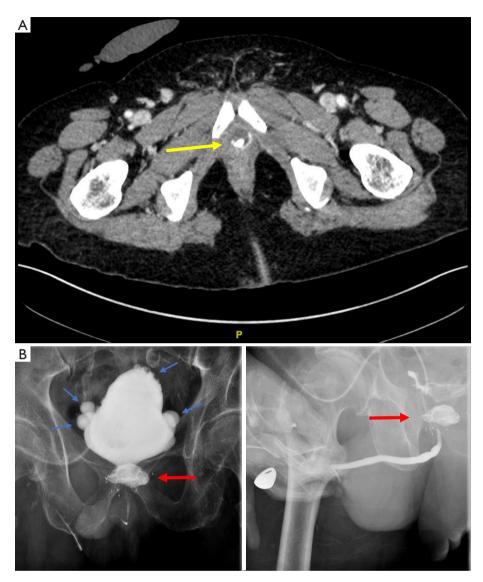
Urethral complications. (A) A 68-year-old male with history of prostate cancer s/p EBRT with pelvic pain, recurrent urinary tract infections, and prostatic urethral calcifications. Computed tomography images show prostatic urethral calcifications (yellow arrow). (B) An 84-year-old male with history of prostate cancer s/p brachytherapy and EBRT with posterior urethral stenosis. Retrograde urethrogram and voiding cystourethrogram images are shown with necrosis of prostate fossa with cavitation (red arrows) and multiple bladder diverticula indicating chronic high pressure voiding due to obstruction (blue arrows). s/p, status post; EBRT, external beam radiotherapy.
